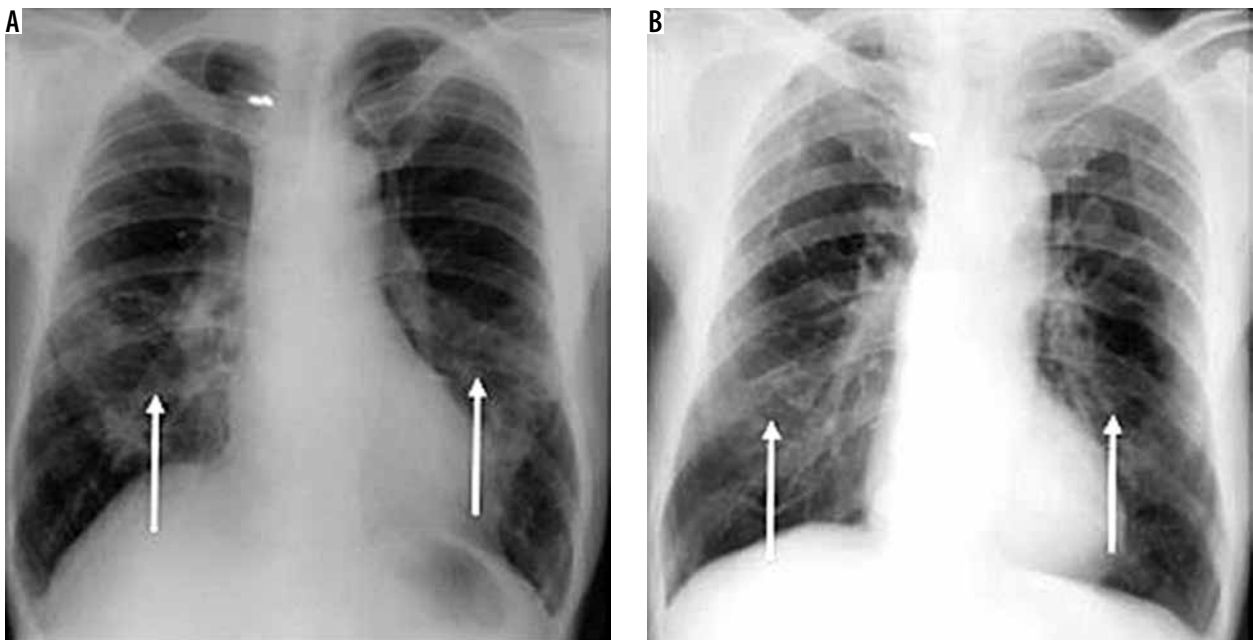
Chest X-ray images of non-tuberculous mycobacteria lesion (indicated by black arrow). Barcode number: (A) 143137, (B) 124475
